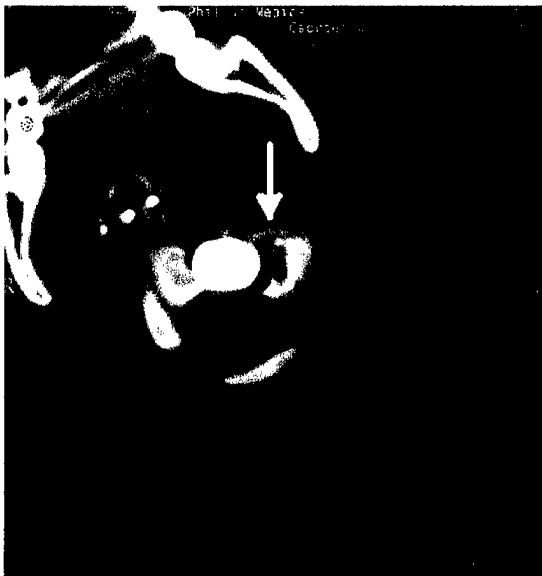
Intraoperative CT with Omnipaque contrast shows residual tumor in left lateral mass after initial resection (arrow).
